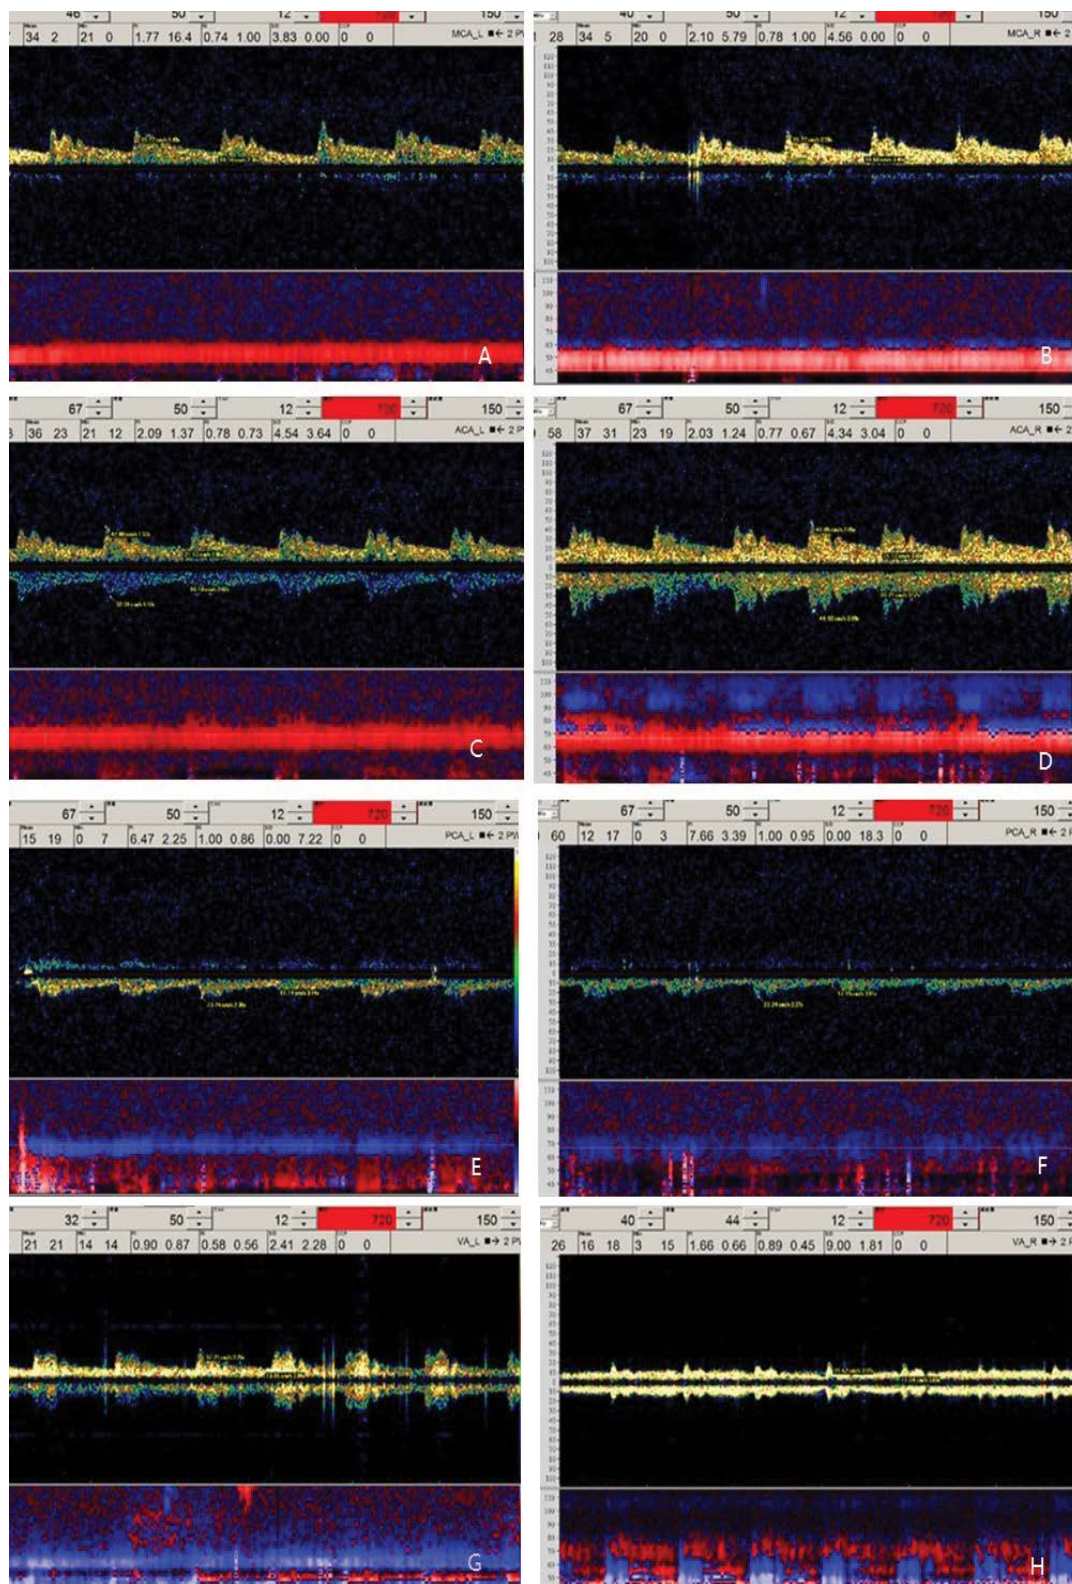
Transcranial Doppler ultrasound indicated that the flow rate of the middle cerebral arteries, anterior cerebral arteries, posterior cerebral arteries, vertebral arteries and basilar artery, were the low, but with the normal range). A: the velocity of left middle cerebral artery: 39/18cm/s; B: the velocity of the right middle cerebral artery: 38/18cm/s; C: the velocity of the left anterior cerebral artery: 32/16cm/s; D: the velocity of the right anterior cerebral artery: 44/20cm/s; E: the velocity of the left posterior cerebral artery: 23/11cm/s; F: the velocity of the right posterior cerebral artery: 22/11cm/s; G: the velocity of the left vertebral artery: 32/13cm/s; H: the velocity of the right vertebral artery: 20/10cm/s.
